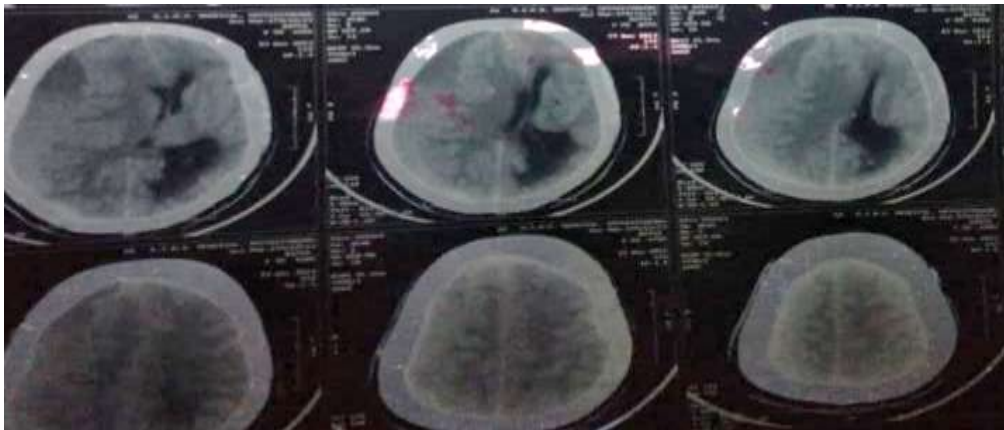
MRI showing subdural haemorrhage
